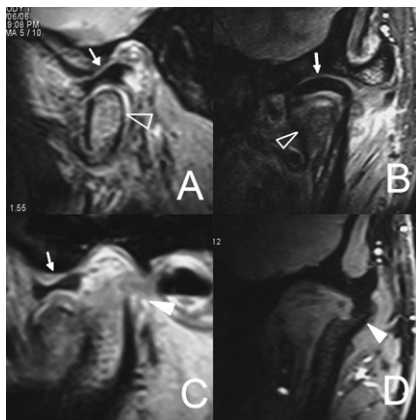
MRI images of type III SFMCs. (A and B) The fractured fragment (hollow triangle) was covered by an articular disc (arrow) on the sagittal (A) and coronal (B) sections. (C and D) The lateral pole (solid triangle) was not covered by the articular disc on the sagittal (C) and coronal (D) sections.
